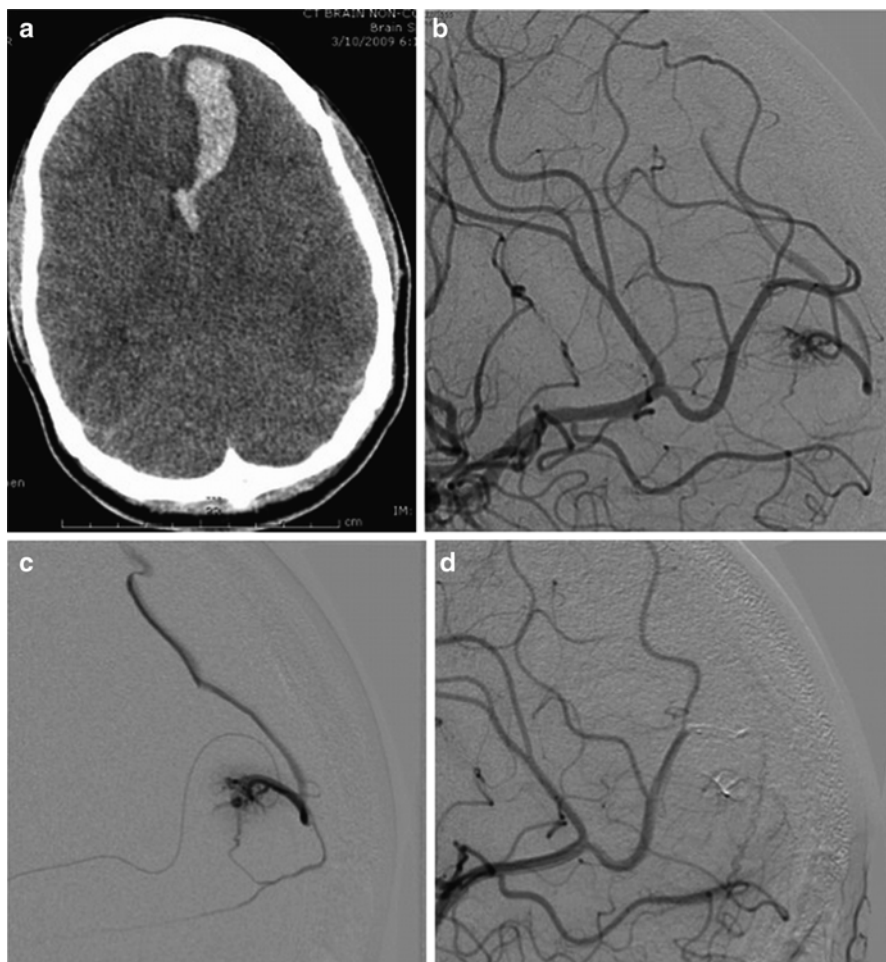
Non-contrast head CT showing a left frontal lobe hemorrhage (a). Lateral projection angiogram showing a PAVF between the left frontopolar branch and a cortical vein (b), confirmed on microcatheter angiogram (c). Complete occlusion is shown after embolization with Onyx 18 (d)
